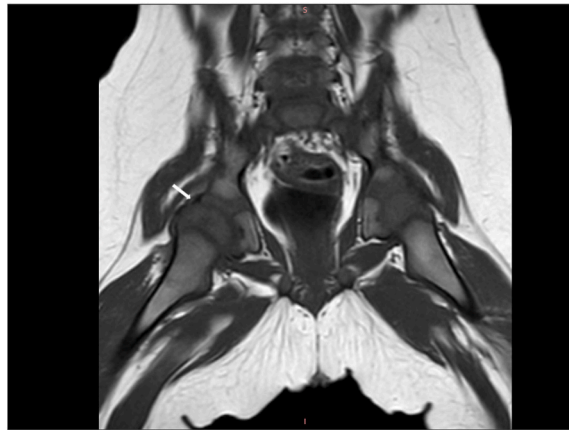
Dynamic changes in the patient's hip X-ray from one month to one year after surgery. Fig. 5A. Hip X-ray (Nov. 21, 2021) shows swelling and blurring of soft tissues (white arrow marking), destruction of the epiphysis, uneven density, and small shape in the center of secondary ossification of the femoral head, with no signs of bone marrow edema. Fig. 5B. Hip X-ray (Dec. 6, 2021) shows no obvious soft tissue swelling but a further size reduction in the secondary ossification center of the femoral head (white arrow marking). Fig. 5C. Hip X-ray (Feb. 23, 2022) shows no obvious swelling in soft tissues but the loss of the secondary ossification center (white arrow marking). Fig. 5D. Hip X-ray (Oct. 31, 2022) shows the shortening of the epiphyseal femoral neck, enlargement of the epiphysis, and reduction of the density (white arrow marking).
